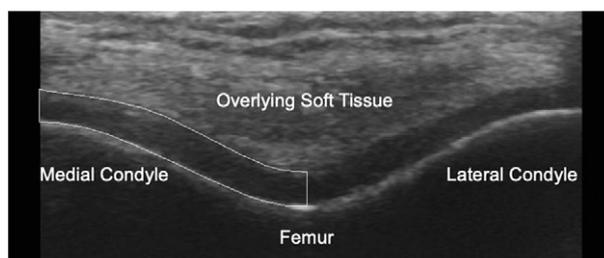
Ultrasonographic image of the femoral articular cartilage with the medial compartment cross-sectional area outlined.
